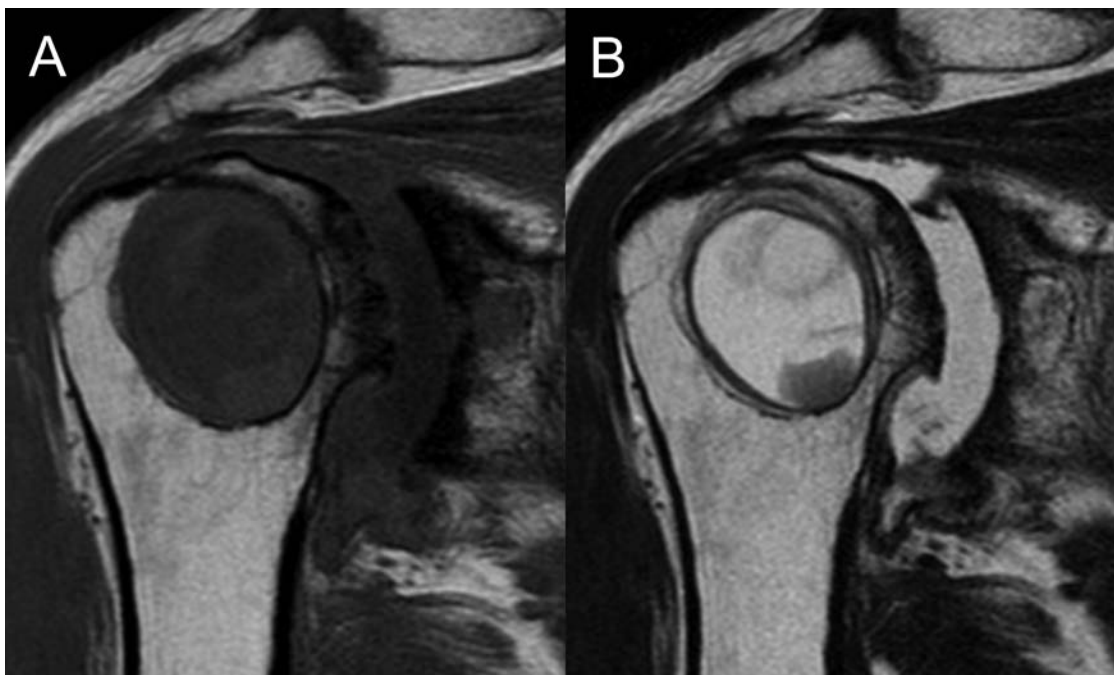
Magnetic resonance imaging of the right shoulder shows a large cystic lesion and proliferation of the synovium at the humeral head. (A) T1 coronal image, and (B) T2 coronal image.
